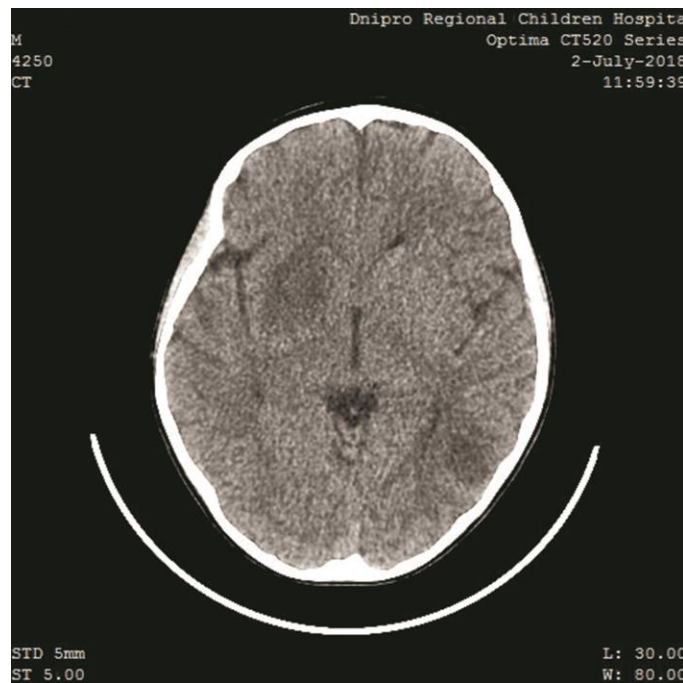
Cerebral CT image: The right anterior deep brain area with the compression of the lateral ventricle
